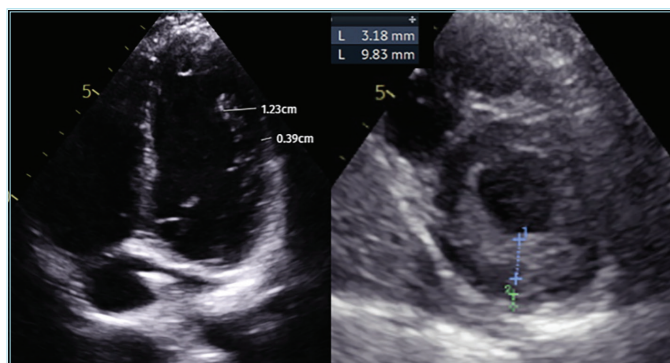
In echocardiographic images of the left ventricle, an increased non-compacted-to-compacted ratio was observed in measurements obtained during the end-diastolic phase, in the right long-axis and left short-axis views
